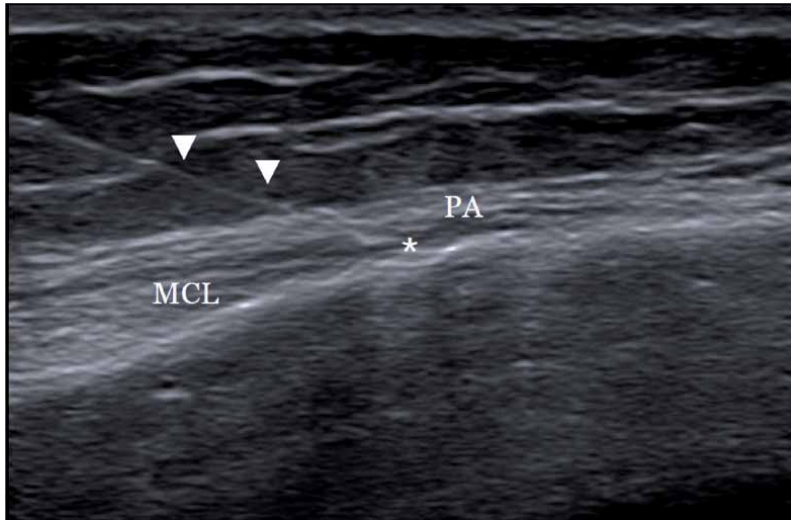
US-guided injection, longitudinal ultrasound image of a needle (arrowhead) in the pes anserinus bursa (asterisk) between the medial collateral ligament (MCL) and the pes anserinus (PA) tendon.
